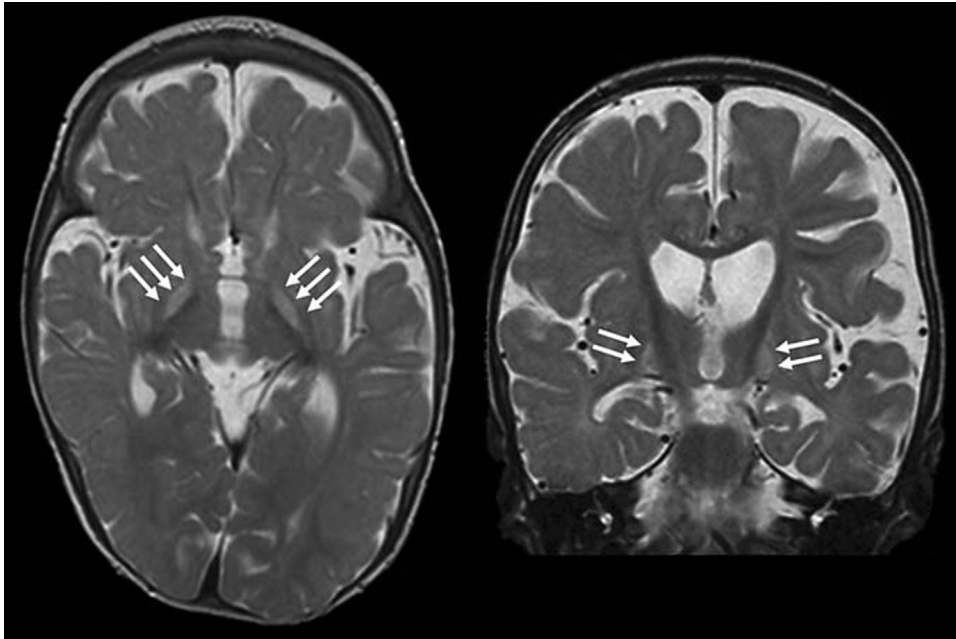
T2-weighted MRI of a 4-month-old corrected-age former 26^{0/7} week gestation preterm infant with low bilirubin kernicterus⁷ demonstrating marked white matter volume loss as indexed by increased extra-axial fluid, ventriculomegaly (hydrocephalus ex vacuo), and thinning of the corpus callosum. The infant also shows increased signal intensity in the globus pallidus (arrows) consistent with chronic bilirubin encephalopathy.⁷ The infant was 860 g at birth, had a peak TSB of 9.9 mg/dL on day of life 8, history of anemia, left heart failure, and grade II intraventricular hemorrhage and on developmental follow-up showed dyskinetic cerebral palsy, marked psychomotor retardation, and bilateral sensorineural hearing loss.⁷ (Reprinted with permission from Moll et al.⁷ Copyright © 2011 Karger Publishers, Basel, Switzerland.)
